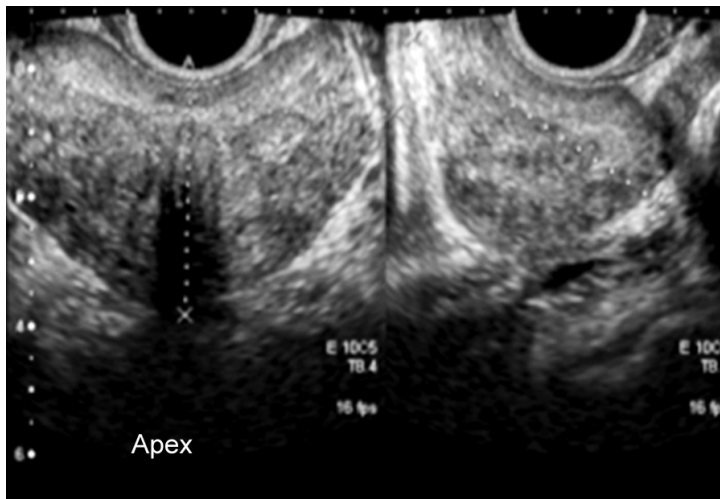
Transrectal ultrasonography for prostate volume
